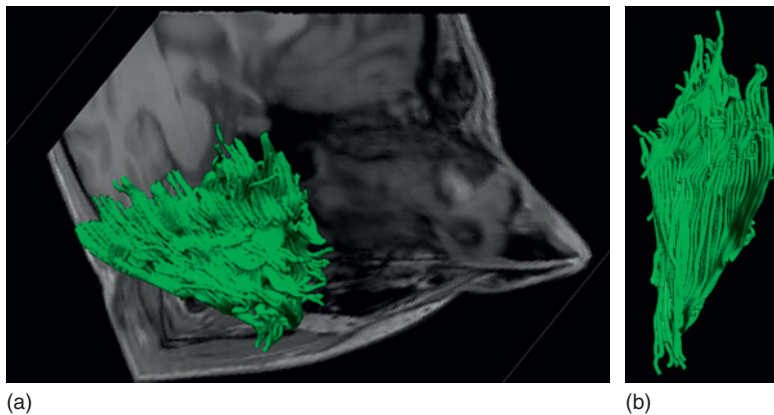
(a) The orientation of the muscle fibers for the temporalis muscle superimposed onto a structural magnetic resonance image. (b) The temporalis muscle seen from the posterior view.
